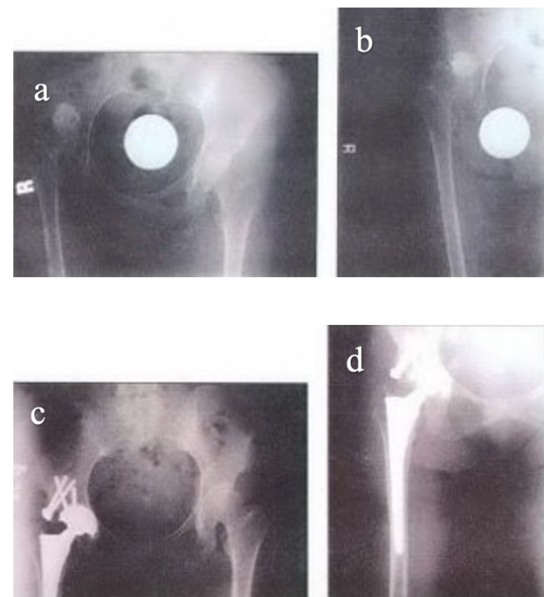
A 49-year-old female patient with coxarthrosis secondary to DDH: preoperative anteroposterior pelvic x-ray (a), preoperative right hip x-ray (b), postoperative 24-month anteroposterior pelvic x-ray (c) and postoperative 24-month right hip x-ray (d)
